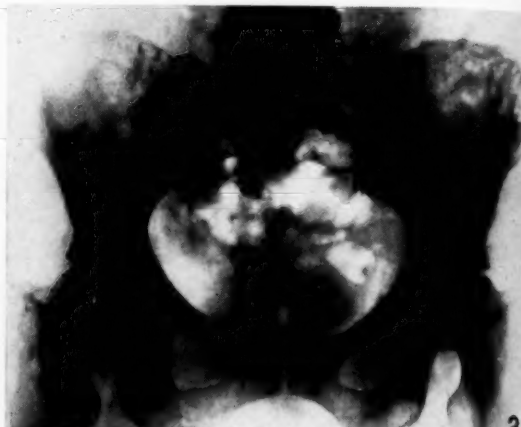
X-ray of pelvis on 16 November 1954.
